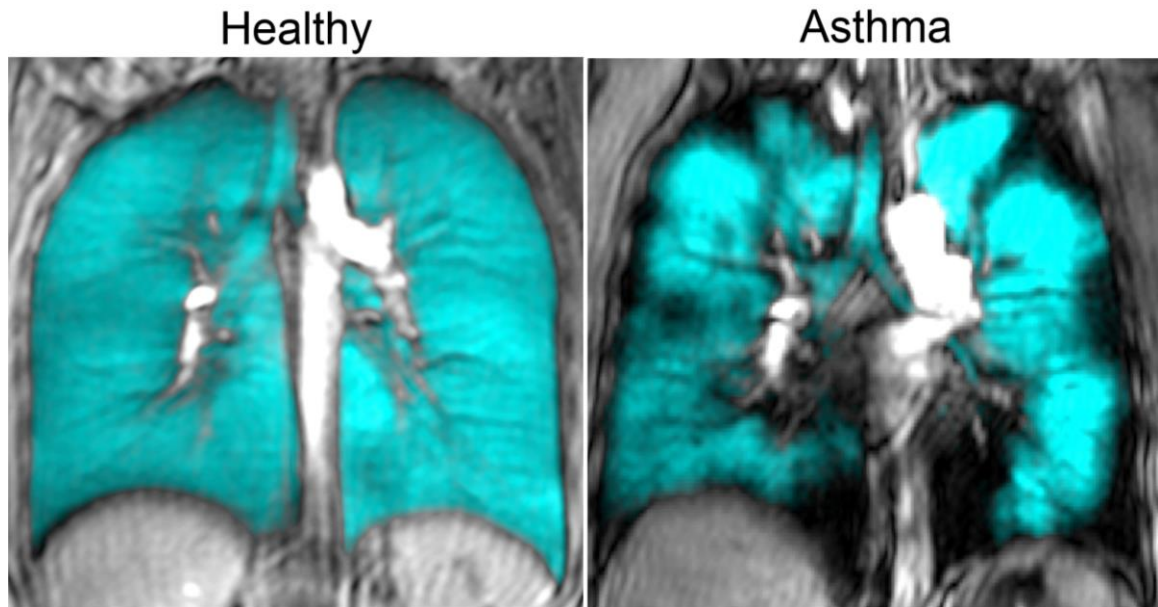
Representative coronal centre slice hyperpolarized ^3He MRI of a healthy volunteer and an asthmatic subject.
